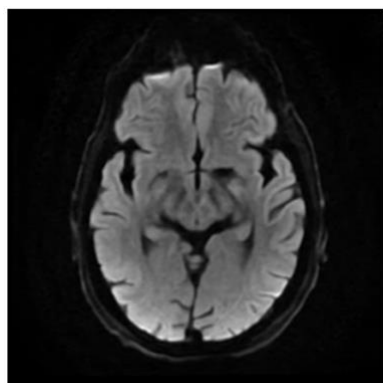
MRI findings at the level of the midbrain
